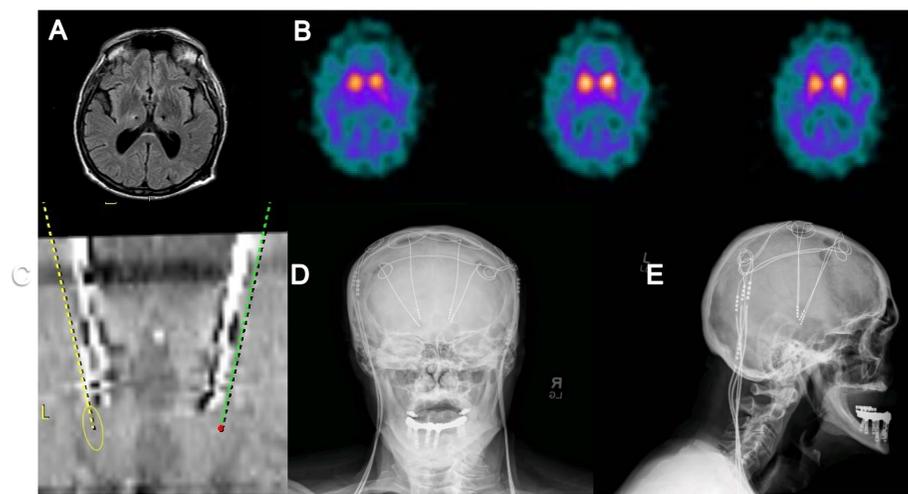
A- Pre-operative MRI showing bilateral ViM electrodes in good position. B- DaTscan showing presynaptic dopamine deficiency. C- Coronal view, 15 degrees from mid plane, showing pre-operative planned trajectories for bilateral STN DBS in relation to bilateral ViM electrodes previously in place (Medtronic StimPilot™). D, E- X-ray of the skull in antero-posterior and lateral views showing the 4 lead placements.
